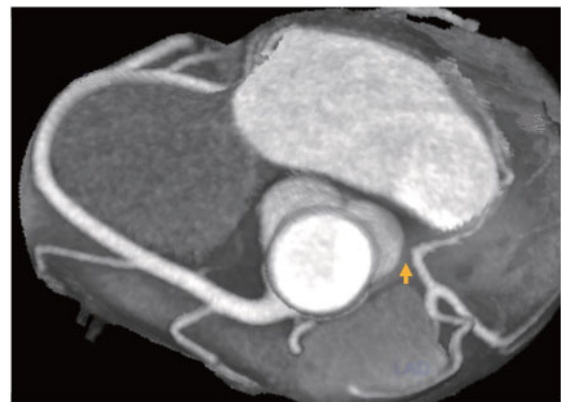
Coronary computed tomography angiography confirmed absence of true left main trunk (yellow arrow).
